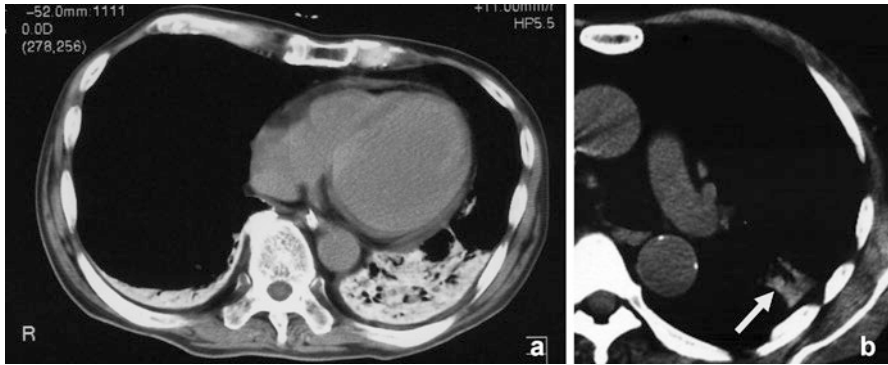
Panel (a) Chest X-ray and (b) CT scan of a patient with ARDS/ALI who was diagnosed with amiodarone-induced lung injury (the author's attended case). A 64-year-old man with congestive heart failure had been treated with amiodarone (200 mg/day) as a maintenance dose. Four years after the start of amiodarone, the patient suffered from a nonproductive cough, dyspnea, high-grade fever, and bilateral diffuse alveolar shadows in a chest radiograph, suggesting pulmonary edema. Right heart catheterization demonstrated a normal pulmonary venous pressure; mean right atrium pressure = 0 mmHg, mean pulmonary arterial pressure = 16 mmHg, mean pulmonary arterial wedge pressure = 10 mmHg, cardiac output = 5.4 L/min
